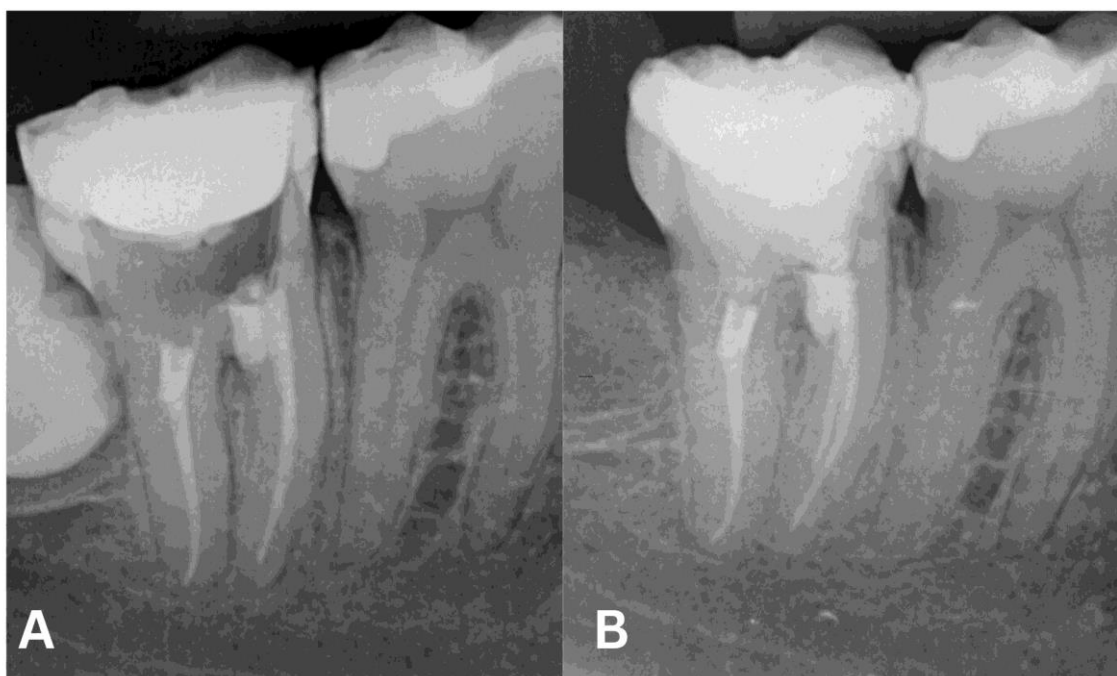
Case 1. Post operative periapical x-rays. (A) completed root canal treatment and temporary filling. (B) Follow up at two years showing no signs of apical pathosis or furcal radiolucency
